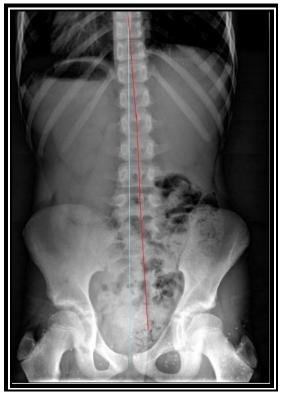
Pre- AP Lumbosacral Radiograph
